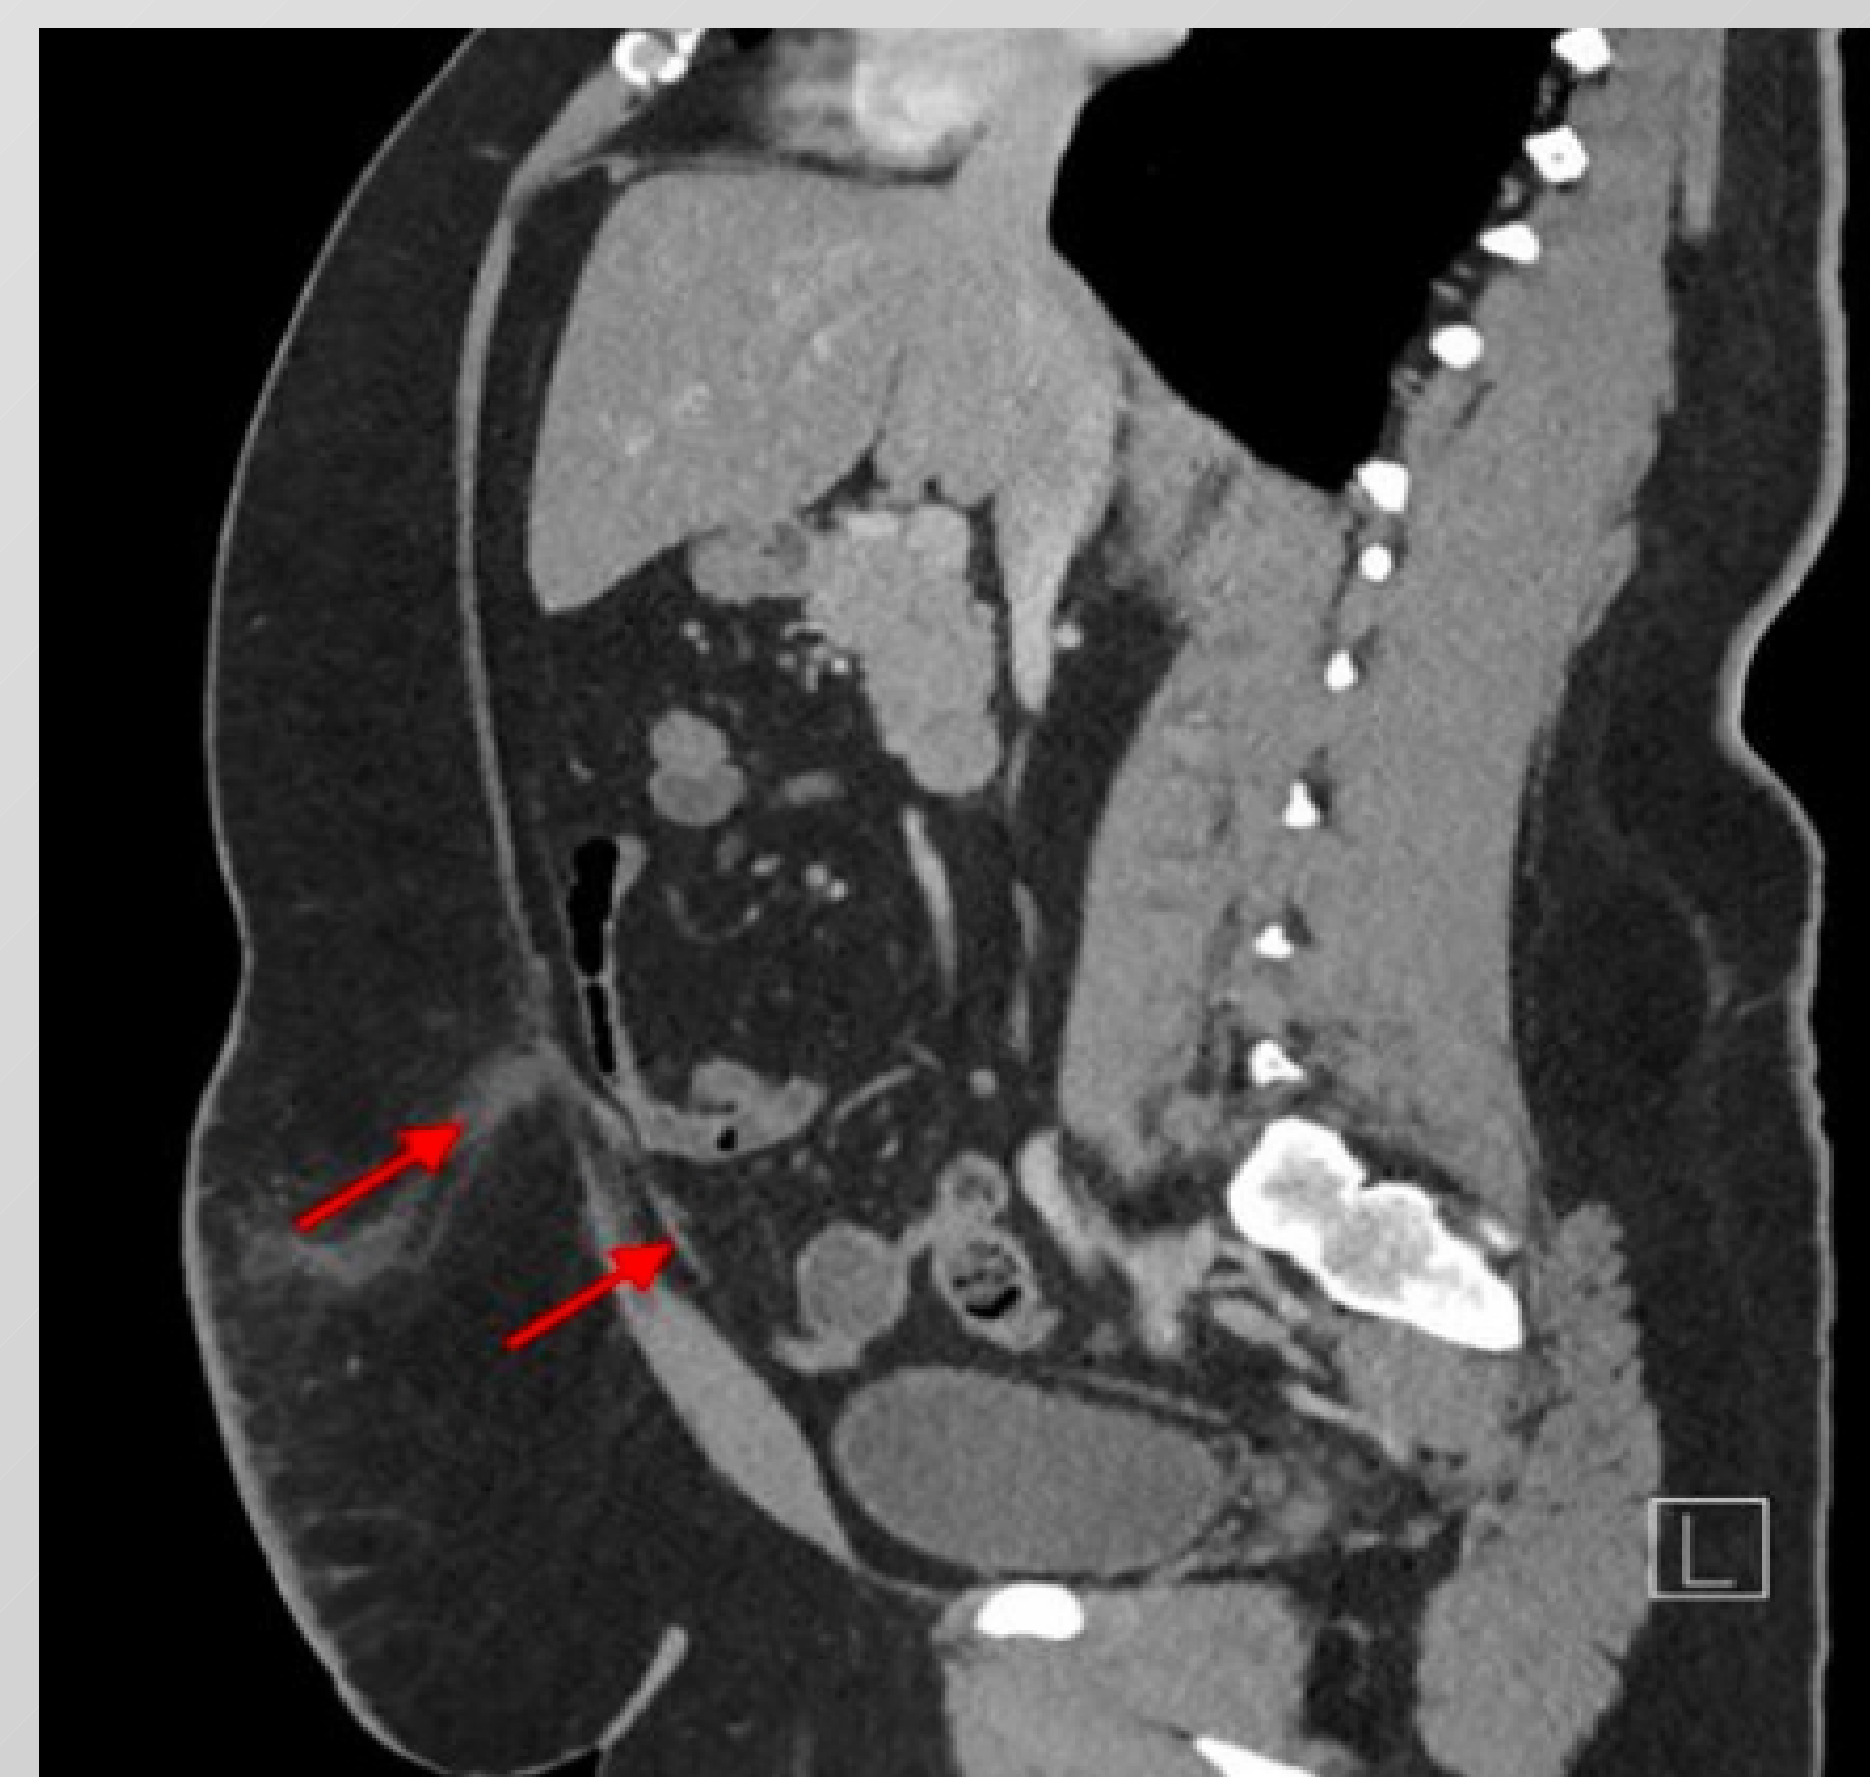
Sagittal CT Image of patient # 3 with infected urachal cyst with red arrows.
